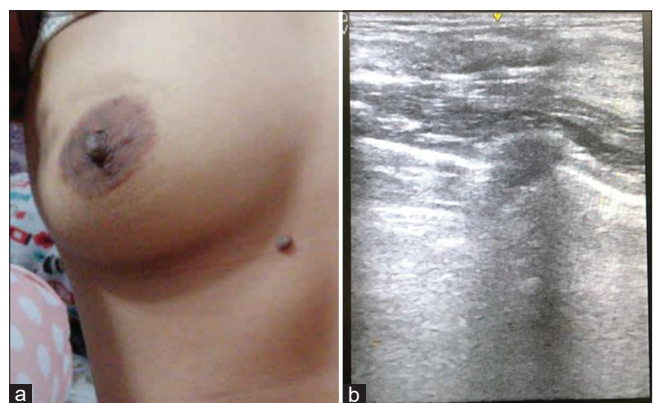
(a) Slight hematoma after vacuum-assisted breast biopsy (VABB), (b) the ultrasound on the right breast a month after VABB
